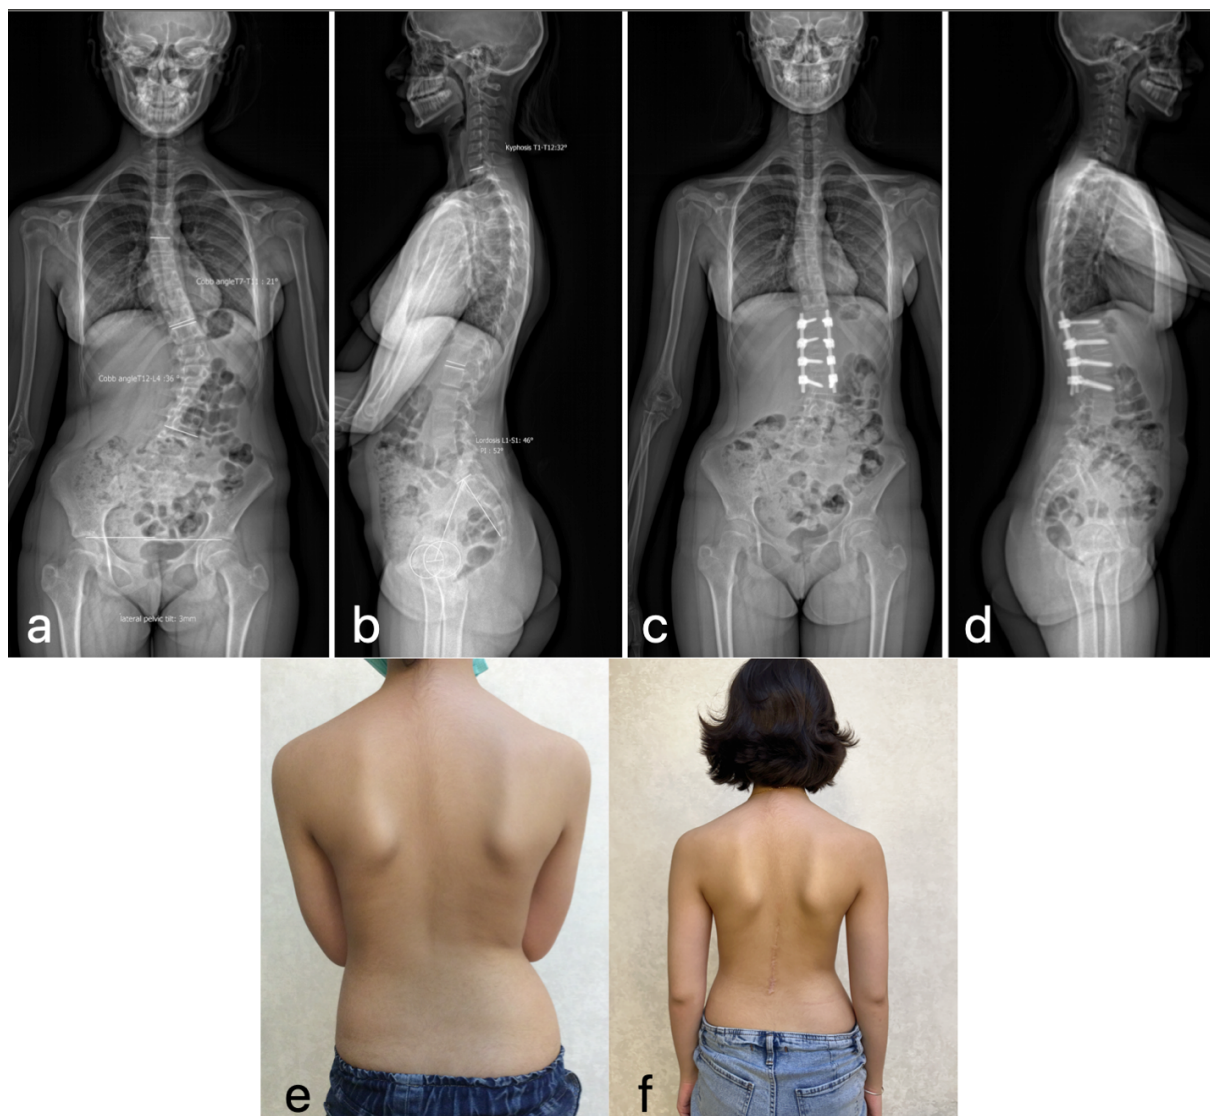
Pre- and postoperative radiographic and clinical images of a patient with a moderate curve who underwent selective short PSF for scoliosis correction
